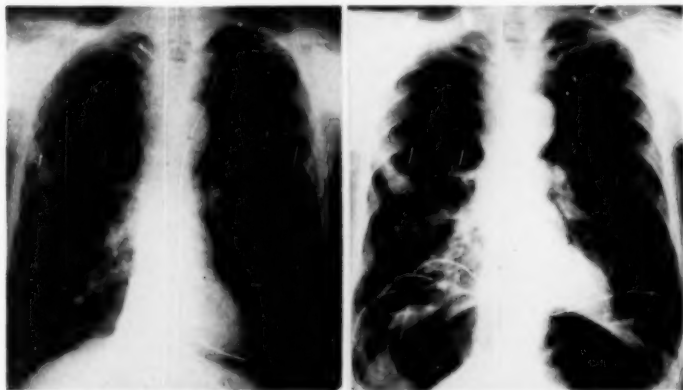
Case 2: From posteroanterior x-ray films taken before and after artificial pneumoperitoneum. These and figures 3, 4 and 5 were taken in the maximal inspiratory position. Another film was immediately obtained, in each instance, in the maximal expiratory position. The former film was then carefully superimposed on the latter, and the position of the diaphragm in maximum expiration indicated by crayon. The increased excursion made possible by pneumoperitoneum is readily apparent. The scalloped appearance of the right leaf of the diaphragm seen in the post-treatment film is thought to represent diaphragmatic crura.
